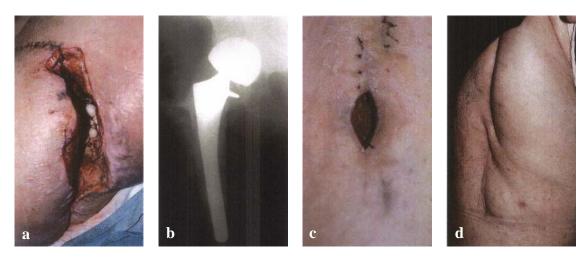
Patient 1, wound 3.(a) Hip prosthesis infected with Methicilline-resistant Staphylococcus Aureus. (b) Radiograph of the infected hip prosthesis. (c) Before chamber treatment, the wound was debrided and closed, except for the inferior 4 cm, to fit the opening of the wound chamber. A 'Z-plasty' was used to strengthen this partial wound closure. After 21 days of treatment with wound chamber and antibiotics, the skin wound was excised and closed. (d) Healing was achieved without recurrence.
